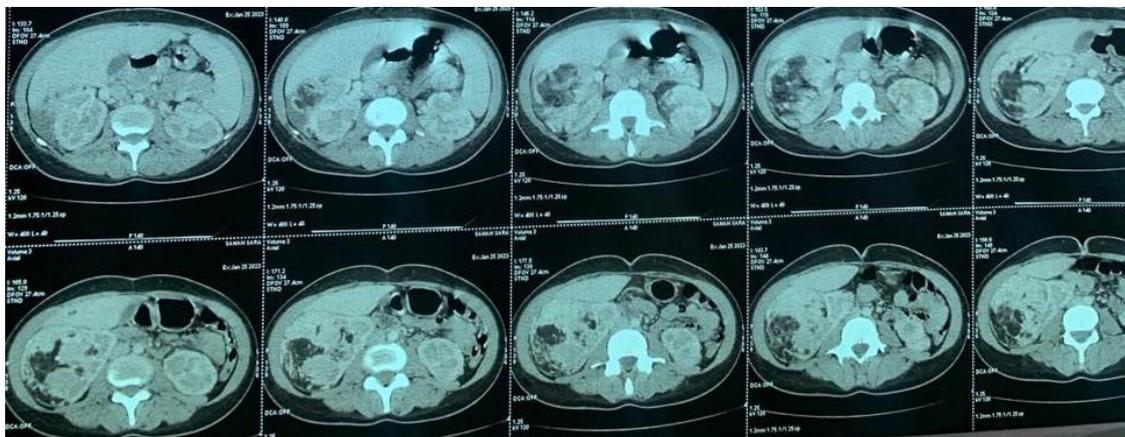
Abdominopelvic CT scans: showing a large mass with dual fatty and tissue components
